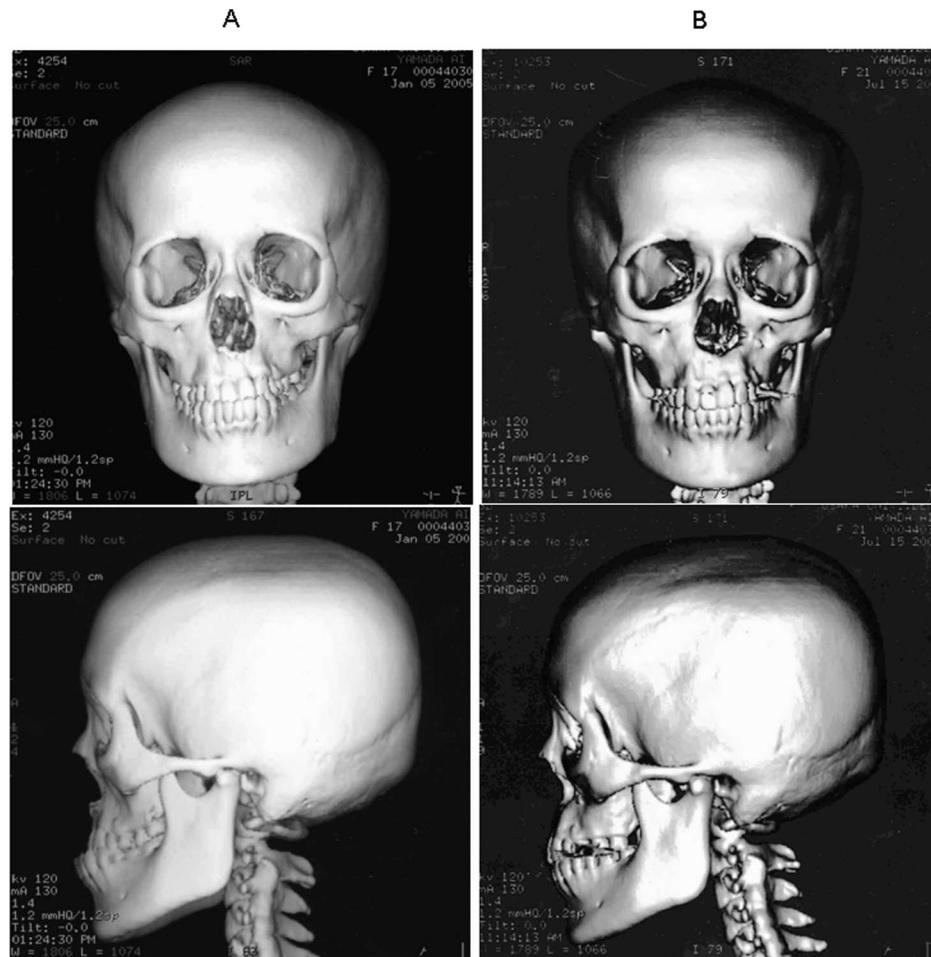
Computed tomography radiographs. (A) Pretreatment (17 years 11 months). (B) 1 year after treatment (21 years 1 month).
